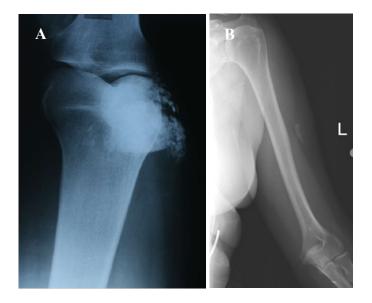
Net-like fine granular dystrophic calcinosis over the patella on plain radiography (A) and dense granular dystrophic calcinosis of the left arm (B) on plain radiography. Modified figure after own publication.(8)
